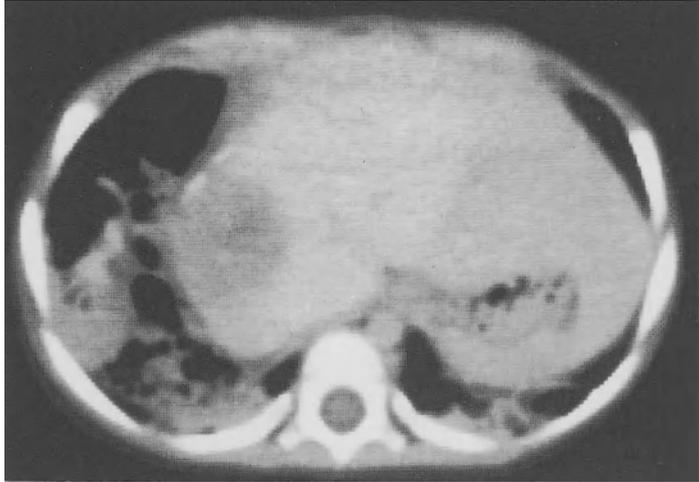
Computed tomography showing local recurrence after trisegmentectomy. This investigation was preceded by a rise in α -fetoprotein levels. The recurrence was successfully resected
